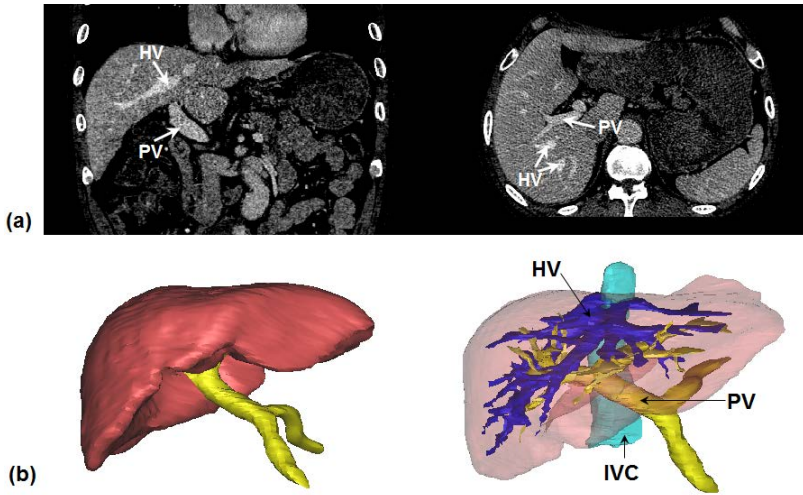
(a) Portal vein viewed from a CT image; (b) digitized liver surface and vasculature
